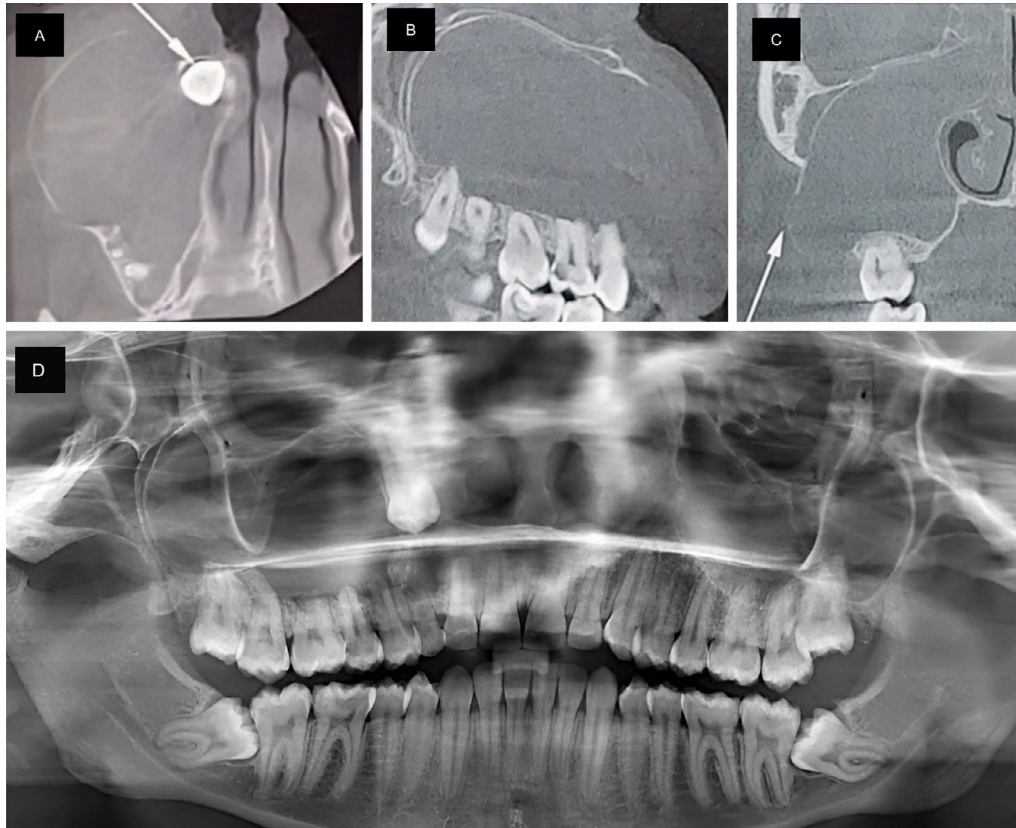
(A) Axial view showing an expansive lesion involving the right maxilla and associated with the impacted tooth 13. (B) Sagittal view revealing the lesion extending toward the maxillary sinus with cortical thinning. (C) Coronal view, with arrow indicating cortical bone thinning. (D) Panoramic radiograph showing an ill-defined radiolucent lesion extending throughout the right maxilla, with a radiopaque area near the apex of tooth 53, displacement of adjacent teeth, and root resorption of teeth 16, 15, 14, and 12.
